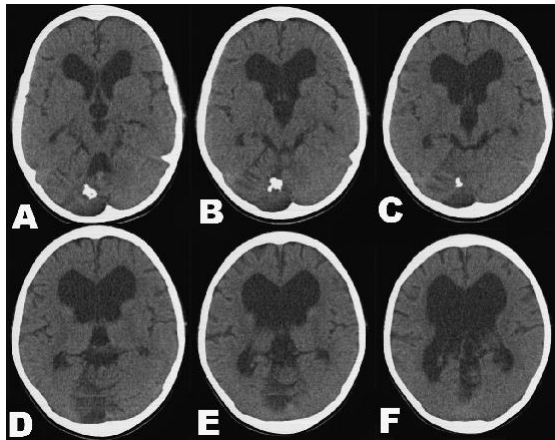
CT scan showing diffuse cortical atrophy, ventriculomegaly and calcification in right cerebellar hemisphere.
